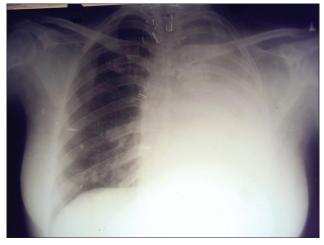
Chest X-Ray PA view: Homogenous opacity of the left side with same side mediastinal shifting—probably left whole lung collapse
